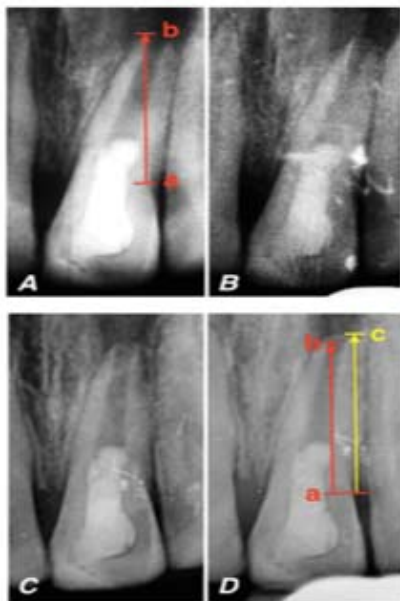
Representative case in TAP; A: preoperative radiograph, B: 6 month follow up radiograph, C: 12 month follow up radiograph, D: 18 month follow up radiograph. Note the increase in root length from (a-b) in the preoperative radiograph to (a-c) in the postoperative radiograph after 18 months of follow up.
